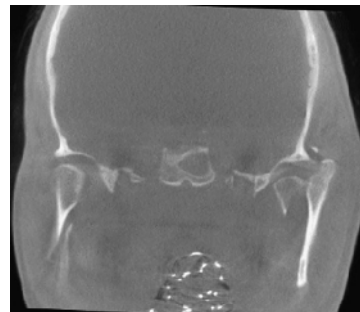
Intraoperative CT image: coronal view of patient 2 revealing the displacement of the left condylar fracture after an attempt at closed reduction.
